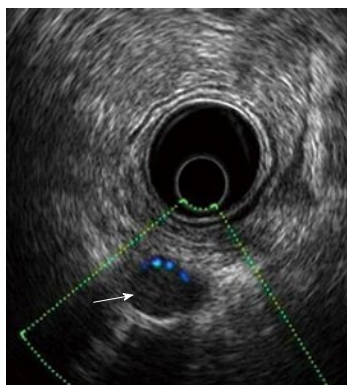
Perirectal metastatic lymph node: Ultrasonographic view. Endoscopic ultrasound with radial array transducer UM160 (5-20 MHz). White arrow: Perirectal metastatic lymph node.
